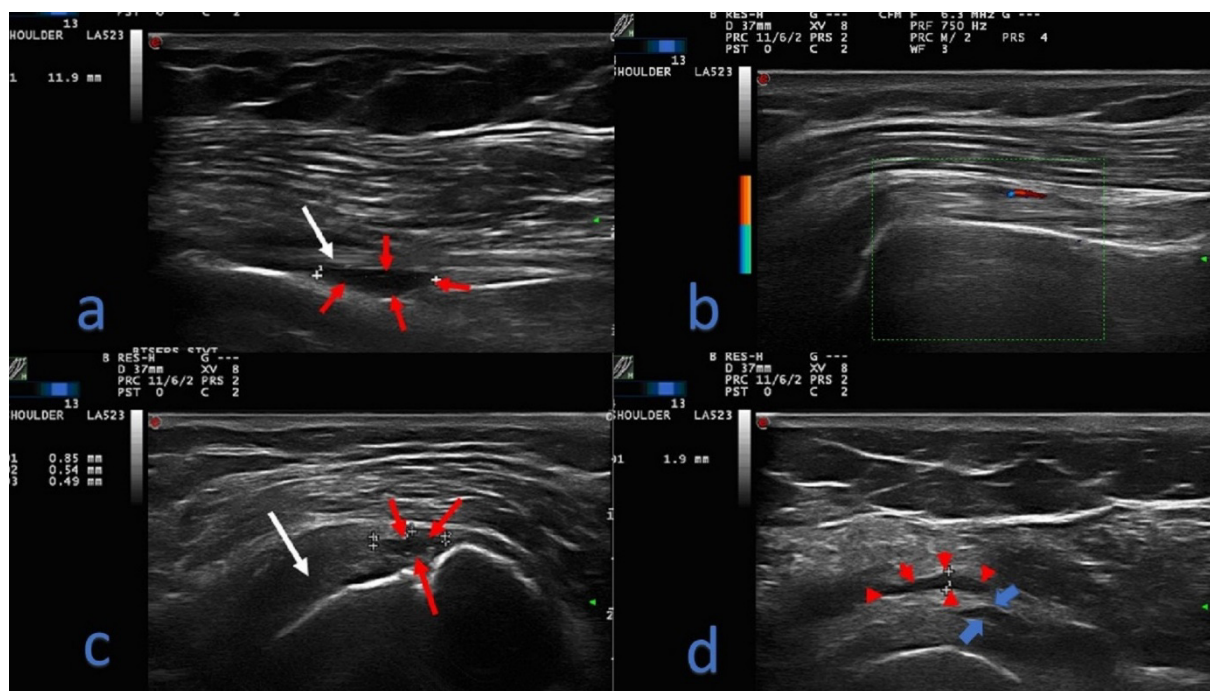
Findings detected by ultrasonography. (a) effusion within the biceps long head tendon sheath, (b) Tenosynovitis of the long head of the biceps tendon, (c) Partial tear of supraspinatus tendon, and (d) Subdeltoid effusion (red arrows) and partial tear of supraspinatus tendon (blue arrows).
